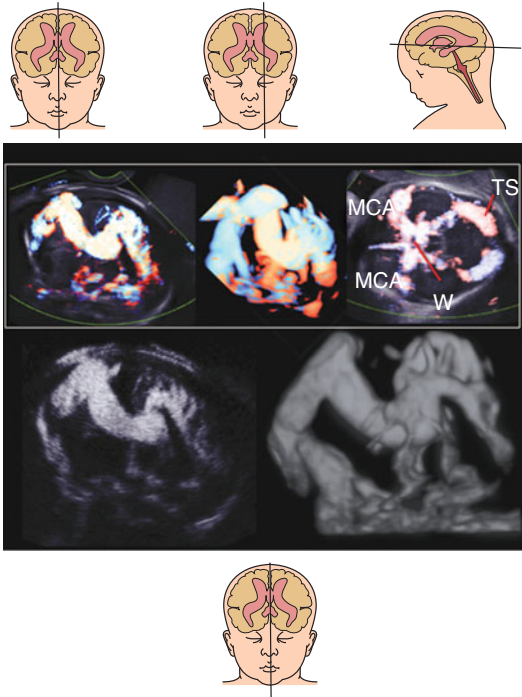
Vein of Galen aneurysmal malformation at 28 postmenstrual weeks. (A) Median section of 2D power Doppler image. The abnormally dilated vein of Galen is demonstrated (left). Lateral view of 3D reconstructed power Doppler image (middle). Axial section of 2D power Doppler image (right). The abnormally dilated middle cerebral arteries (MCA) and circle of Willis (W) are demonstrated. The transverse sinus (TS) is also dilated, and the blood flow direction is in the opposite direction. (B) Median section using 2D B-flow image. The abnormally dilated vein of Galen is demonstrated (left). Lateral view of 3D reconstructed B-flow image (right). This case is a choroidal type vein of Galen malformation with aplasia of the straight sinus. Many of the arteries directly enter into the dilated vein of Galen. This anomaly is considered an abnormal arteriovenous shunt.
